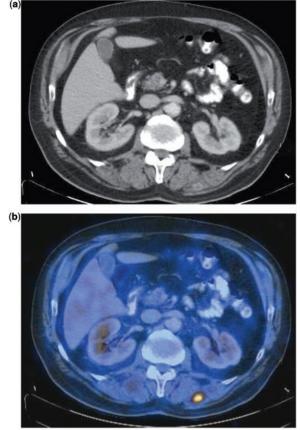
A 53-year-old man with colon cancer. (a) A subtle metastasis to the lumbar muscle as seen on CT. (b) This lesion is easily visible on PET/CT.
